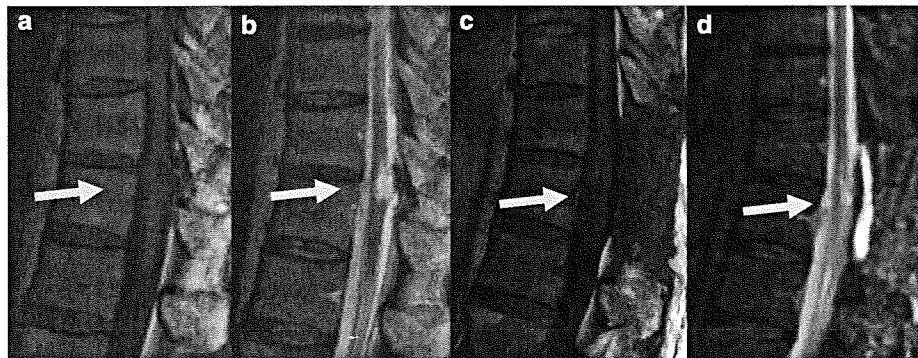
Preoperative magnetic resonance (MR) images ((a) Sagittal T1 weighted, (b) Sagittal T2 weighted) showed syringomyelia at the T11/12 level. Postoperative MR images ((c) Sagittal T1 weighted, (d) Sagittal T2 weighted) showed disappearance of the syringomyelia.
